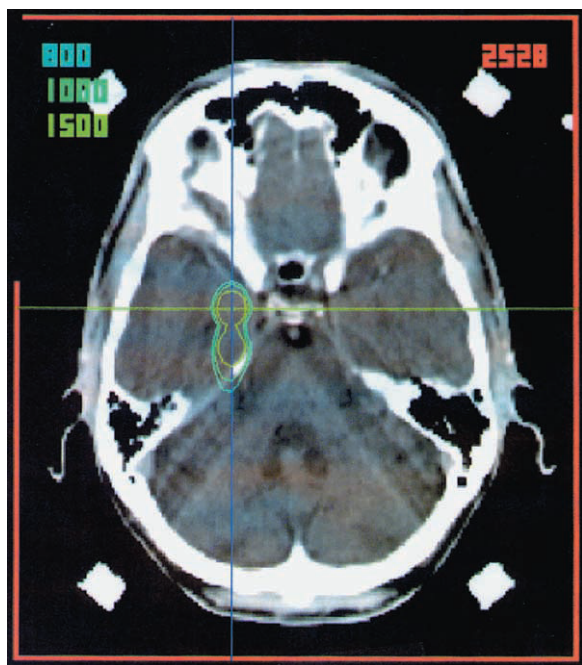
Axial CT image with overlay of isodose distribution using three separate isocenters with collimator diameters of 7, 10, and 10 mm respectively. The prescription isodose line of 1500 cGy covered the target region (amygdala and hippocampus) at 57% of maximum dose. Isodose lines for 1000 cGy and 800 cGy are also shown.
